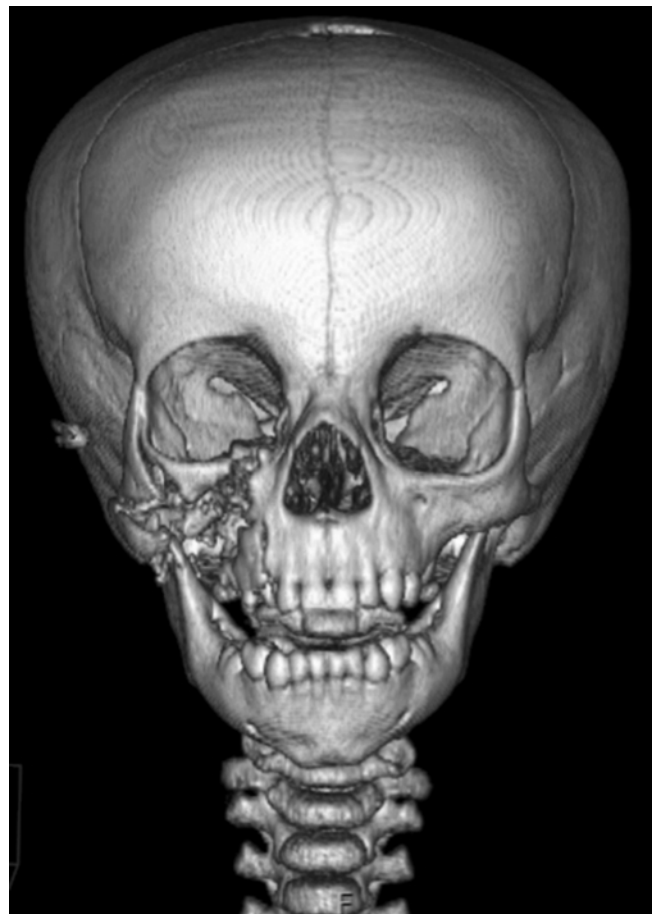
CT scan showing the bony injury. Note the vertical split in the body of the zygoma
